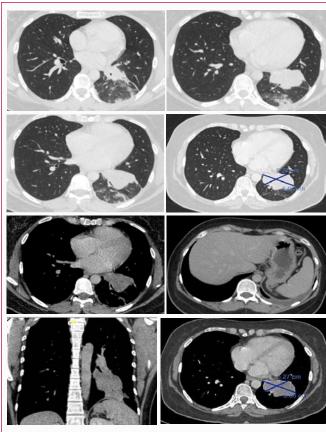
CT chest shows Left lower lobe irregular shaped mass measuring 6.6 cm \times 5.2 cm encasing and partially attenuating the left lower lobe bronchus.
